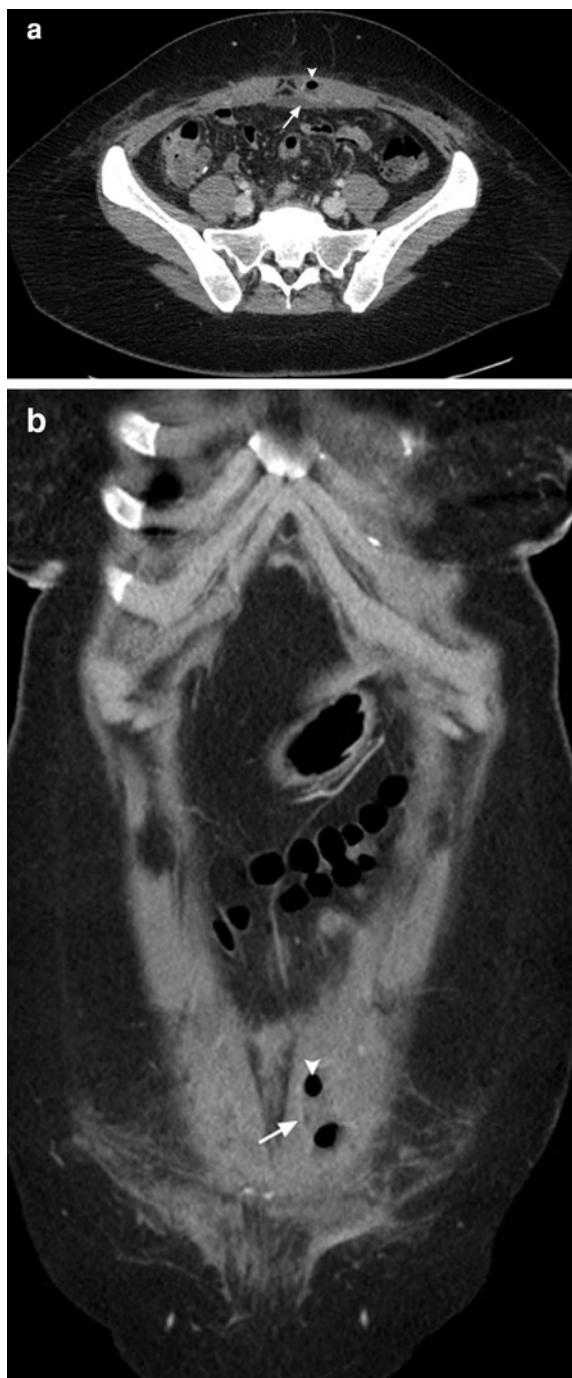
Infected fluid collection within the abdominal wall in a 30-year-old woman 3 weeks after conservative surgery for endometriosis. a, b Axial and coronal contrast-enhanced reformatted CT scans of the lower abdomen show gas within the rectus sheath fluid collection (arrowhead), enhancement of the collection wall, and fat stranding around the collection that was suspicious of an infection (arrow)
